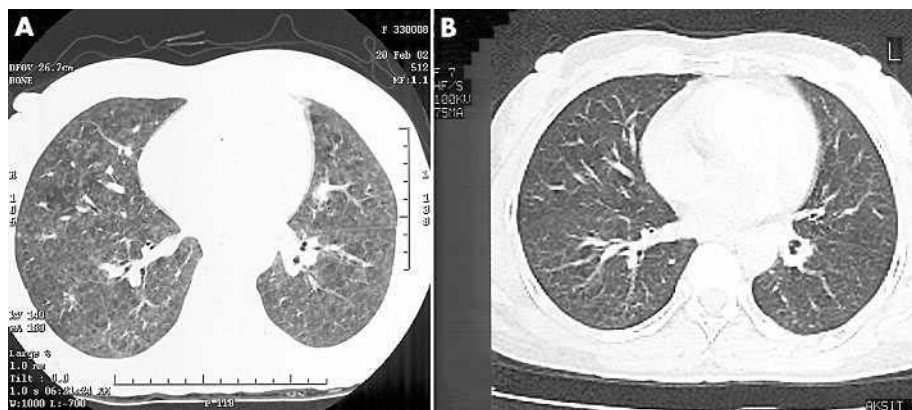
High resolution chest computed tomograms of the chest in case 2 with subacute hypersensitivity pneumonitis: (A) ground glass opacifications and centriacinar micronodules (before treatment) and (B) resolution of the findings (after treatment).
